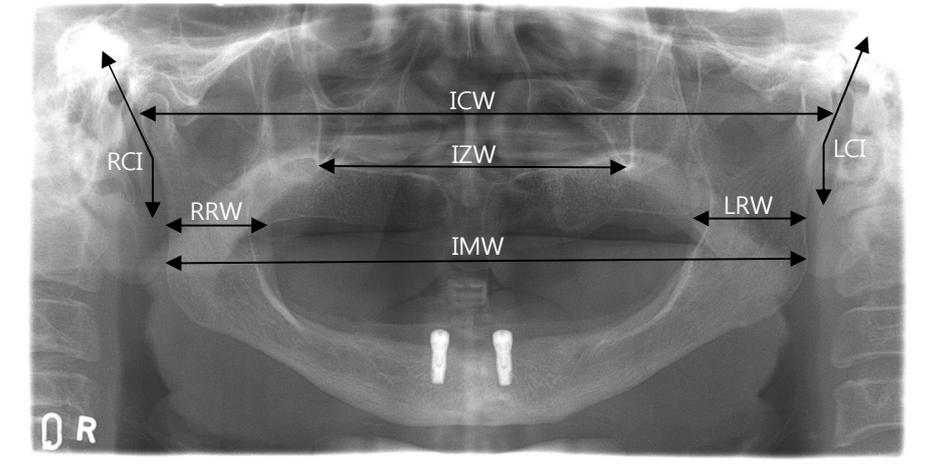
Reference points, lines, and angles of measuring variables are seen on the radiograph. IMW: Width between the farthest distal mandibular angle points, ICW: Width between the farthest distal condyle head points, IZW: Width between the bottom points of innominate line, RRW: Shortest horizontal length of the right mandibular ramus, LRW: Shortest horizontal length of the left mandibular ramus, RCI: Angle between linear line with distal right condyle neck and vertical line, LCI: Angle between linear line with distal left condyle neck and vertical line.
